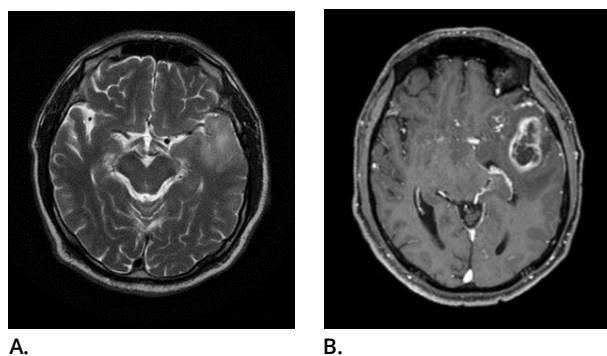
(Case No. 1): A. MRI T2 hyperintensity at first imaging; B. Contrast enhancing T1 MRI showing tumour 7 months later.
